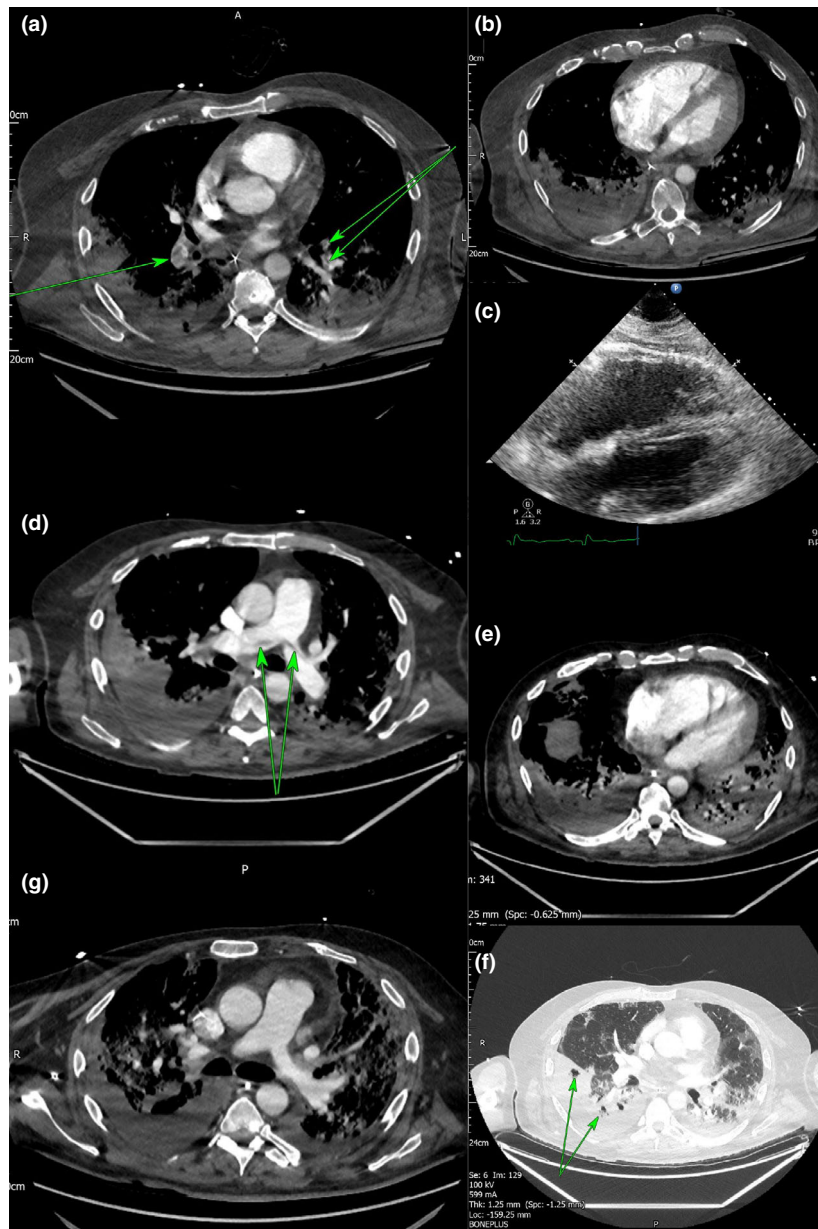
CT pulmonary angiogram on admission demonstrating: (a) bilateral segmental PE; and (b) right ventricular dilatation. Bed-side transthoracic echocardiography demonstrating (c) right ventricular dilatation and flattening of the intraventricular septum. Repeat CT pulmonary angiogram showing: (d) new saddle thrombus; (e) new right ventricular dilatation; and (g) infarcted lung with cavitation. Third CT pulmonary angiogram showing (f) improved clot burden following second episode of thrombolysis. The video URL is: https://youtu.be/Lfhj_bcT4gc
